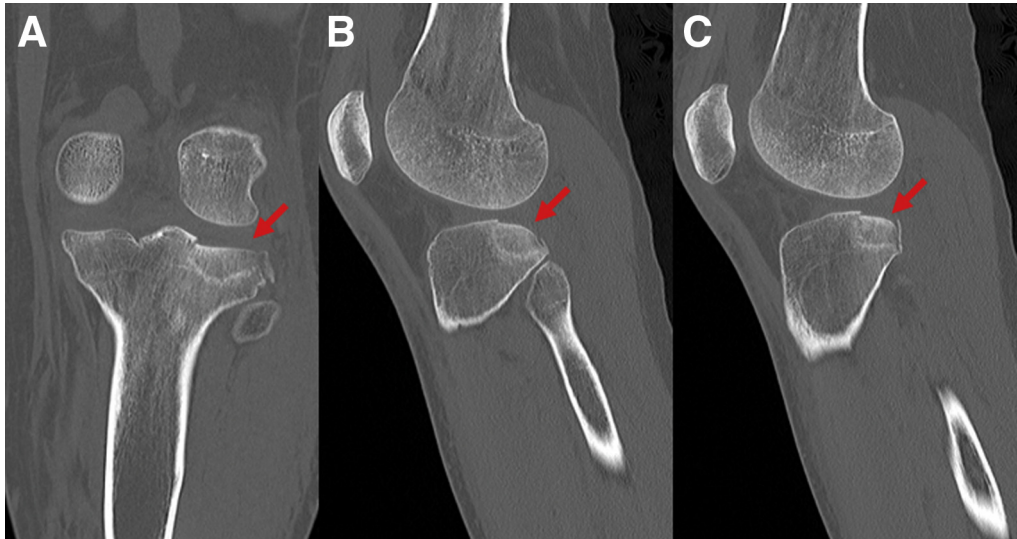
Preoperative computed tomography scan images of a left knee. A fracture of the posterolateral tibial plateau (red arrows) is visualized on the (A) coronal and (B, C) sagittal views. An acute depression of posterolateral tibial plateau slope is visualized on (B), marked by the red arrow.
